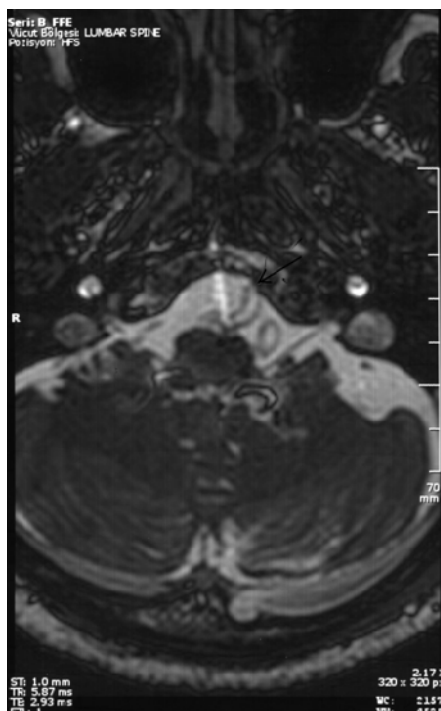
Temporal MRI, axial B-FFE sequence in a 52-year-old woman. Certain identification of the left hypoglossal nerve.
